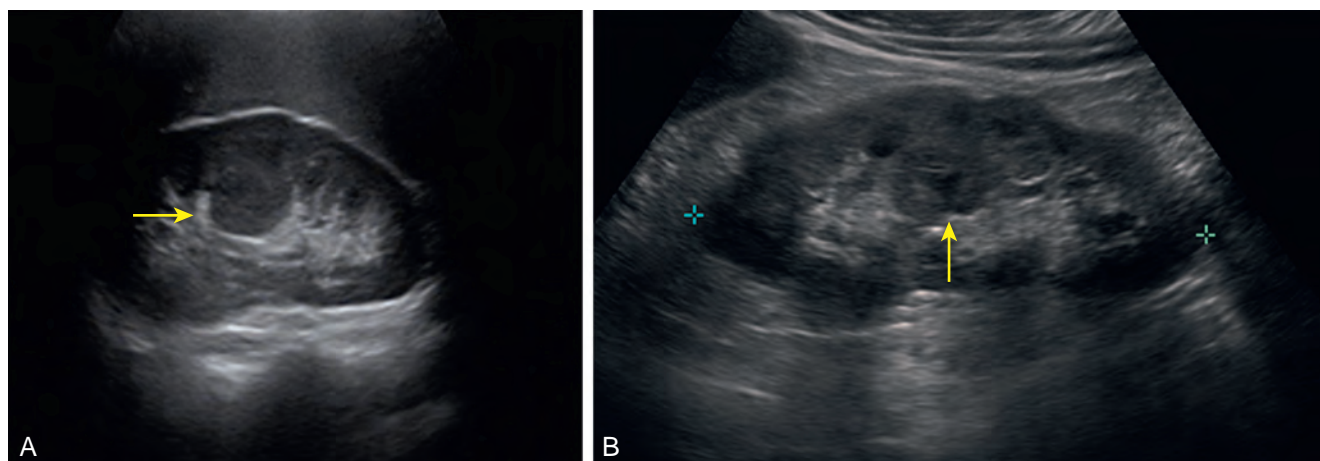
Sonogram of (A) sagittal view of right kidney with hypertrophied column of Bertin (arrow). B, Sagittal view of right kidney showing lobar dysmorphism resulting from malrotation of the renal lobe. The findings of a central echolucent pyramid and a posterior calyx (arrow) are diagnostic.
